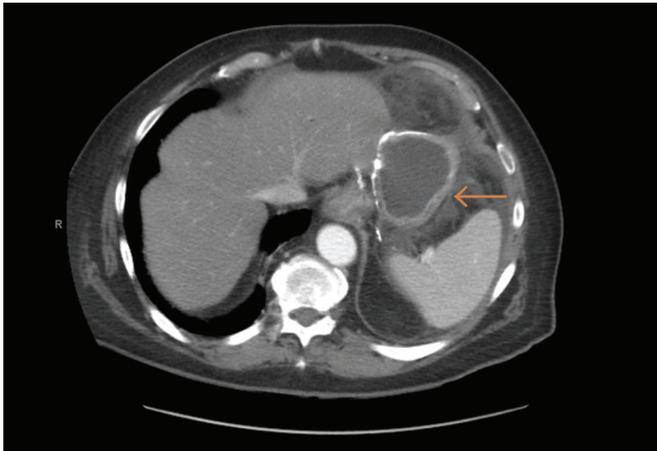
Computed tomography of abdomen showing the excluded stomach (arrow) with adjacent inflammation and mesenteric fat stranding.
